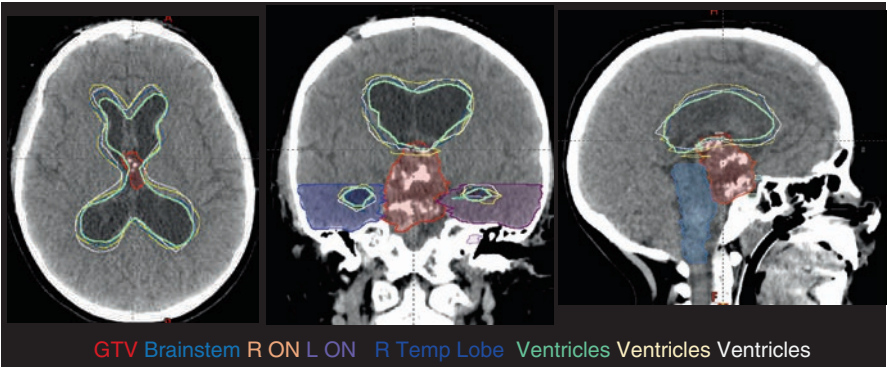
Case 3. Axial planning CT scan of contours for post-op RT planning for progressive ACP
